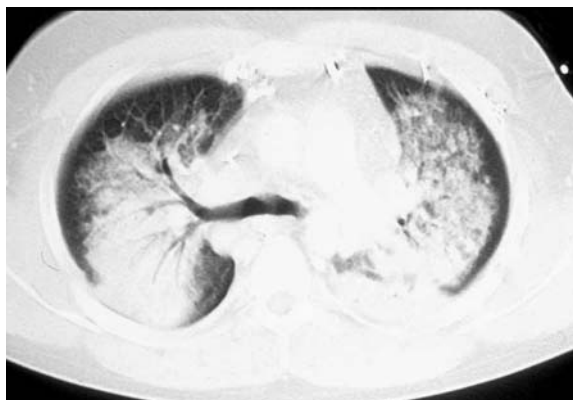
Diffuse alveolar haemorrhage due to Wegener's granulomatosis. A pulmonary CT section at the level of the main carina shows centrally accentuated parenchymal opacities with an air bronchogram on the right side.
